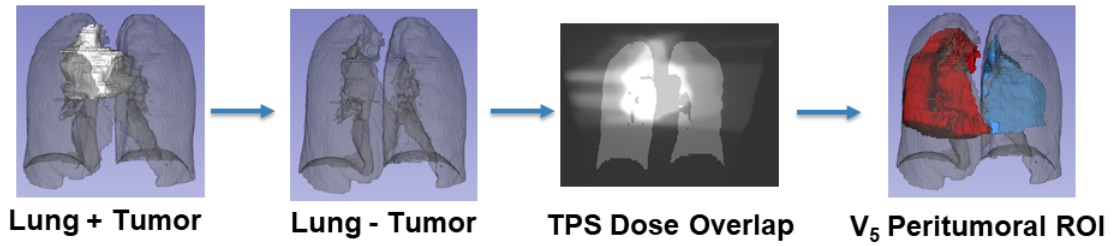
Figure A-19: The process of generating ROI-V5 by using the anatomical (CT) and dose distribution (TPS). The tumor subtracted pulmonary structures were overlaid with the dose distribution to retain a binary pulmonary volume that received ≥ 5 Gy
